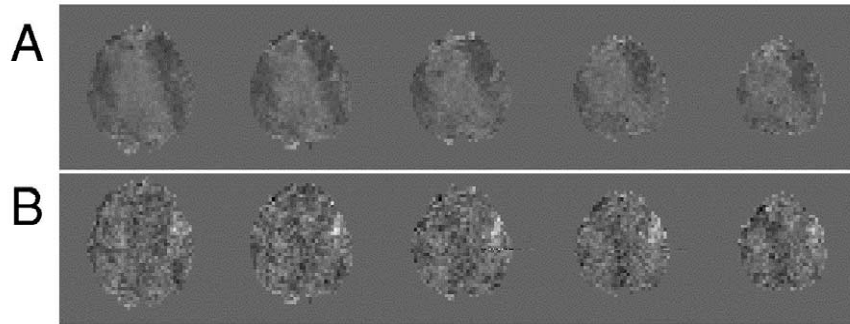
Motion correction during scanning. A schizophrenic patient participated in a fingertapping experiment with a simple block design. Images were acquired with PRESTO (Ramsey et al., 1998). Five slices, out of the 26 scanned, are shown from bottom to top, covering the primary motor cortex. Slices are in radiological orientation (left is right and vice versa). Due to motion, no activity was found in the statistical map (A). During scanning, navigator echoes were acquired, which measure phase changes in the raw MRI signal caused by motion. When these echoes were used to correct motion artefacts during image reconstruction, image stability was greatly improved, resulting in emergence of motor cortex activity (B). This shows the importance of motion correction, especially when studying psychiatric patients as they tend to move more than healthy controls.
